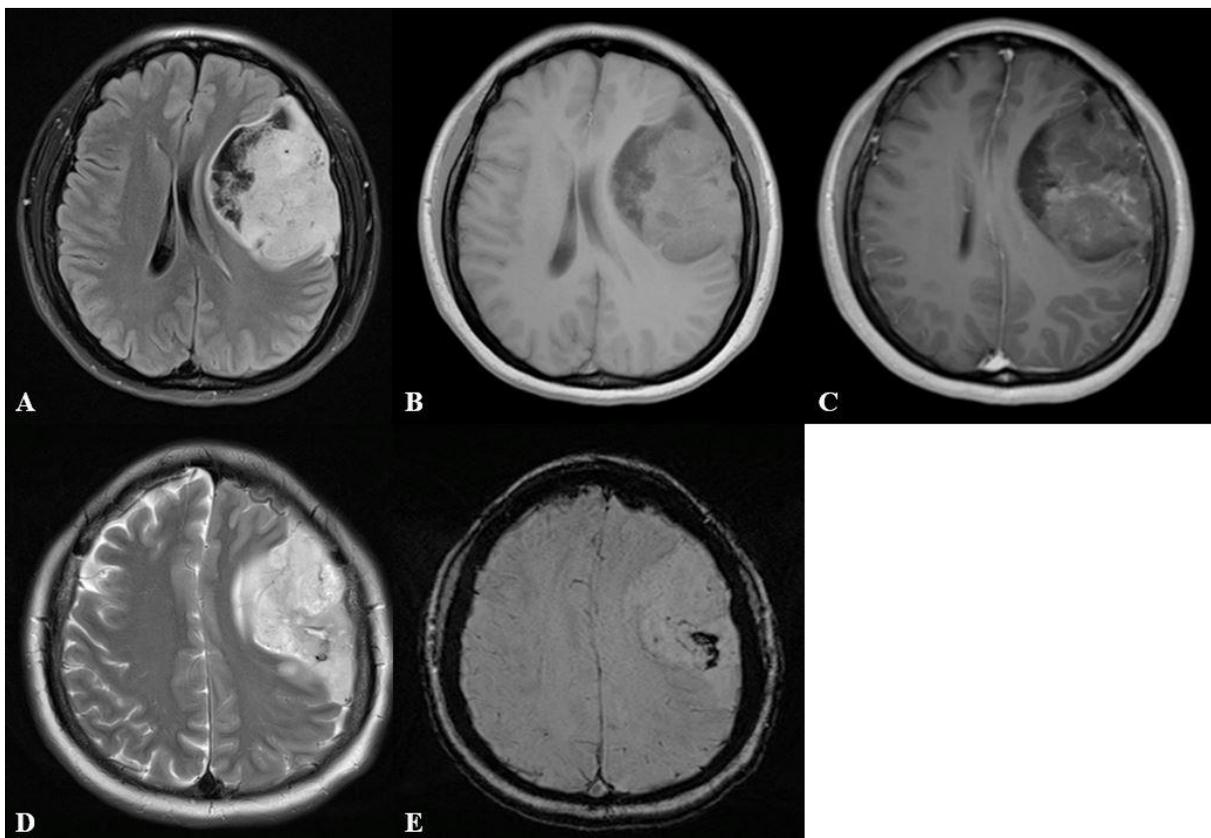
Head MRI of 43 y.o. female with anaplastic meningioma, axial T2-FLAIR (A), T1WI (B), T1 post-contrast (C), axial T2WI (D), and SWI (E). A heterogenous extraaxial mass was present on left frontoparietal lobe with solid and necrotic components. After contrast administration, the mass demonstrated small area of contrast enhancement. There were foci of signal loss and blooming artefact seen on T2WI and SWI, suggesting blood product.
